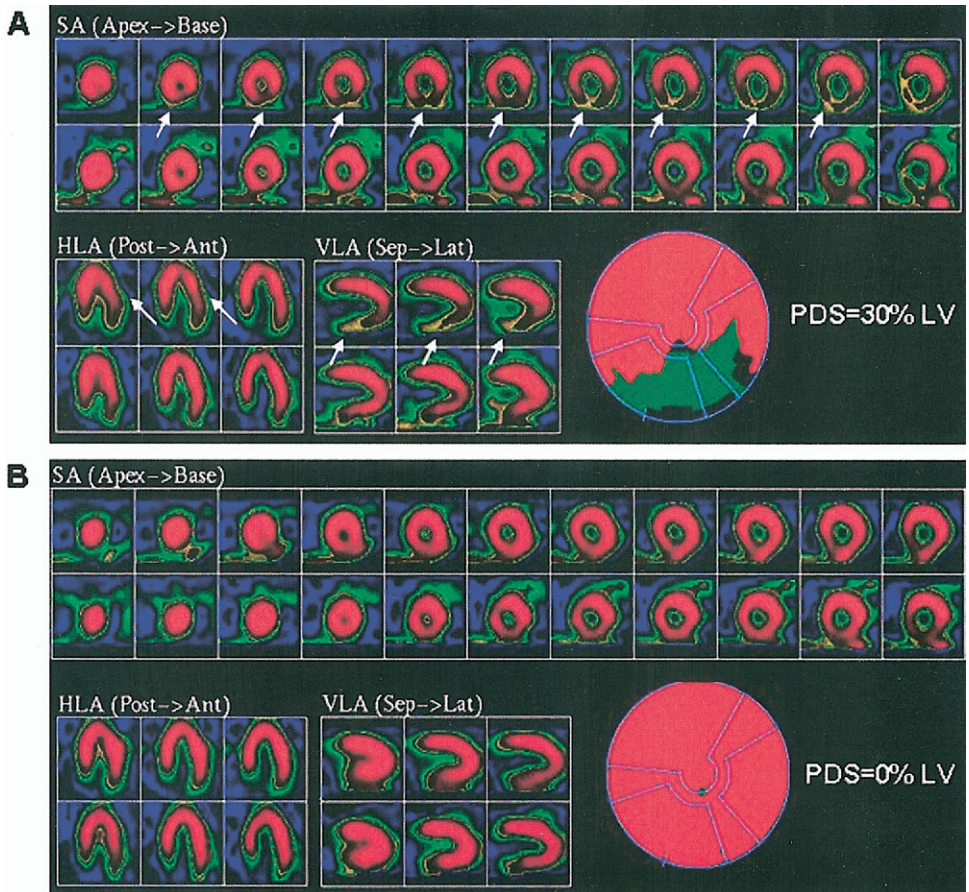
Serial SPECT images and polar plot of a patient randomized to medical therapy. Baseline SPECT (A) shows a large perfusion defect (arrows) in the short (SA), horizontal long (HLA), and vertical long (VLA) axis slices after stress (upper panels) which improves with rest imaging (lower panels). Ischemia is present in the right and circumflex vascular territories. Total LV PDS is 30% with 25% ischemia (green) and 5% scar (black). The patient was treated with a beta-blocker, calcium-channel blocker, and statin. Repeat SPECT (B) is entirely normal. This patient had no subsequent cardiac event. Other abbreviations as in Figure 1.
